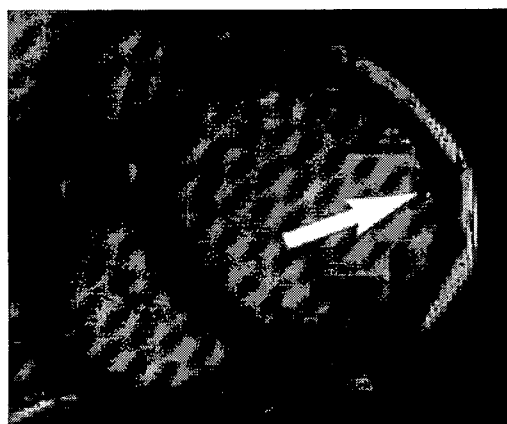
Left ventricular mid short axis view by cardiac magnetic resonance imaging demonstrating thinning of the lateral wall (arrow, measurements ranged from 2 to 4 mm).
